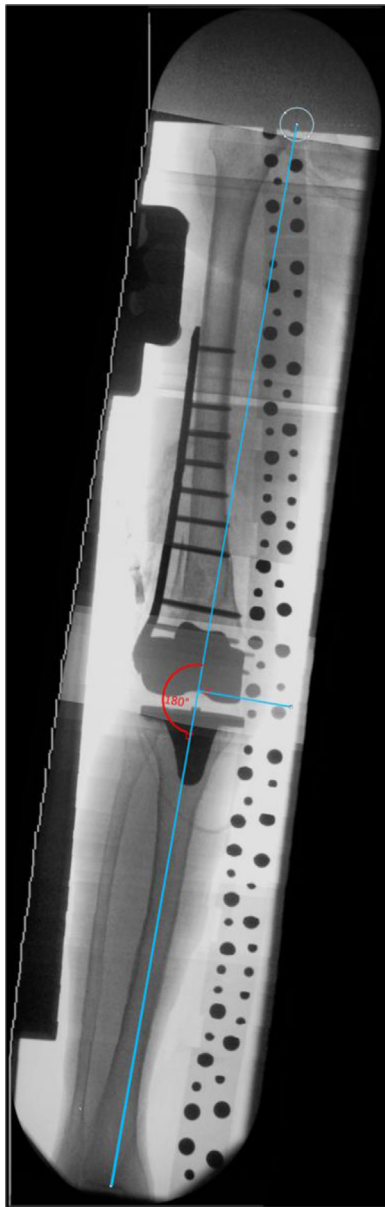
A long leg X-ray was created intraoperatively on a patient with a peri-prosthetic distal femur fracture. The X-ray is created using multiple fluoroscopic shots. These images are stitched by the workstation. The black dots are markers inside the referenced device, which was placed underneath the patient. This can be done pre- or intraoperatively.
